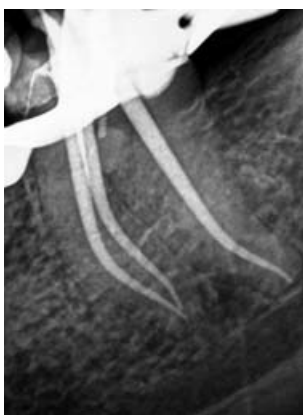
Cone-fit periapical radiograph.
